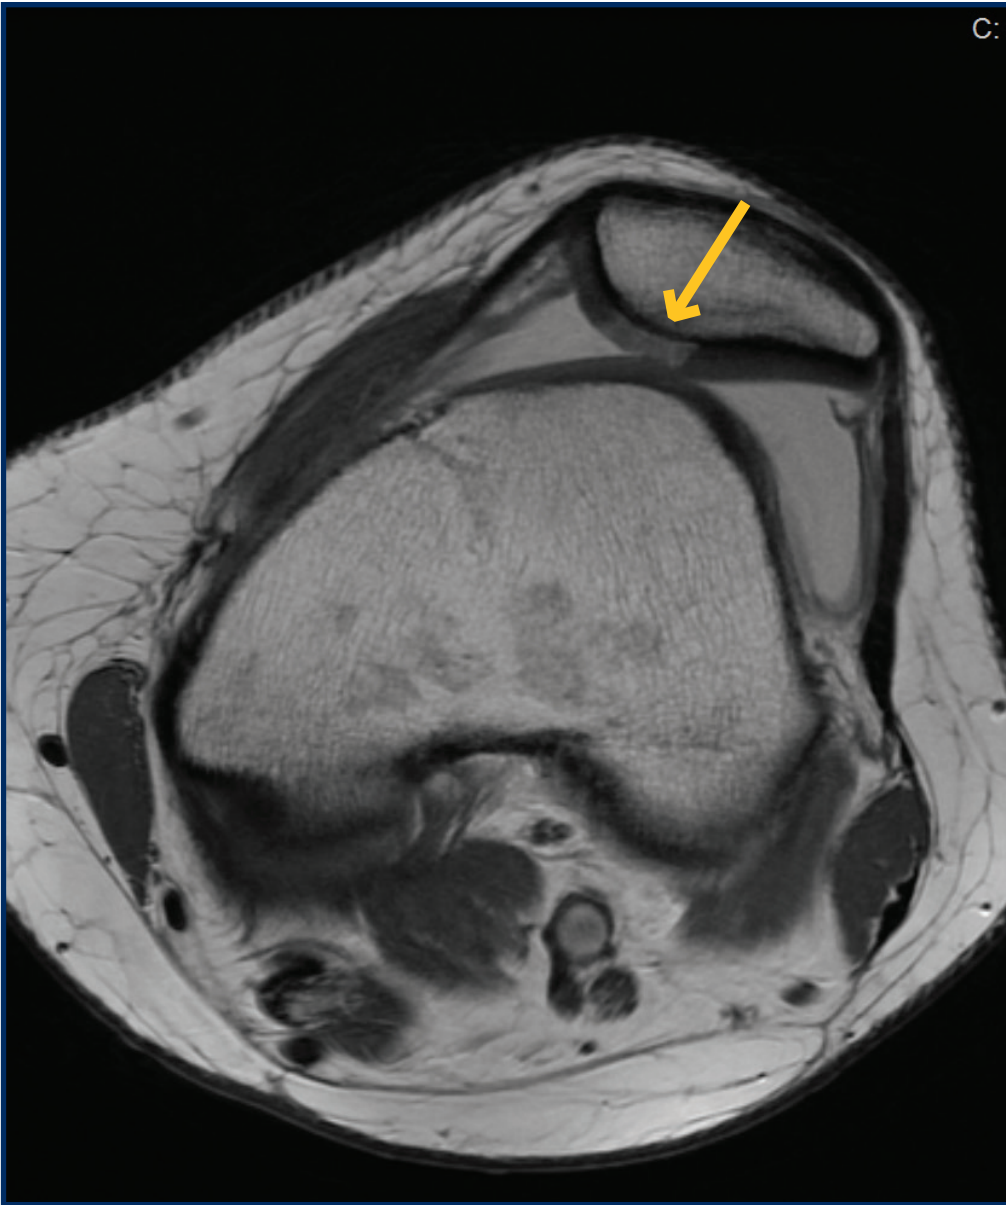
Axial MRI depicting trochlear hypoplasia, lateral patellar subluxation, and central patellar cartilage lesion (arrow).
